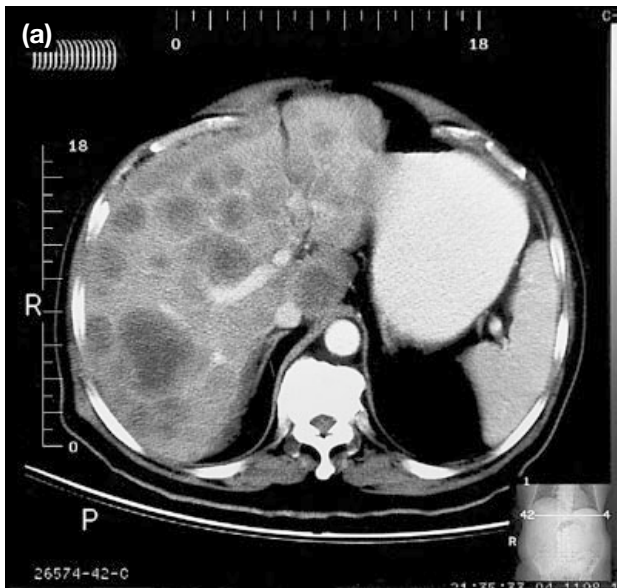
Omental stromal tumour with liver metastases. This 65-year-old man with peritonitis was found at laparotomy to have a ruptured omental stromal tumour. Rapid local recurrence with invasion of mesenteric vessels occurred postoperatively. Contrast-enhanced CT abdomen 18 months later shows (a) multiple rim-enhancing hypodense nodules in the liver and (b) a large primary tumour in the central abdomen.
